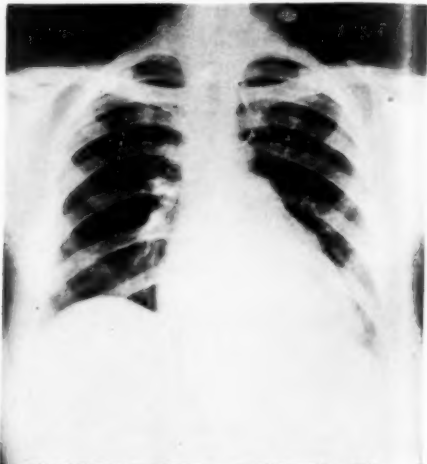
Pre-operative radiographs in Case 1.
